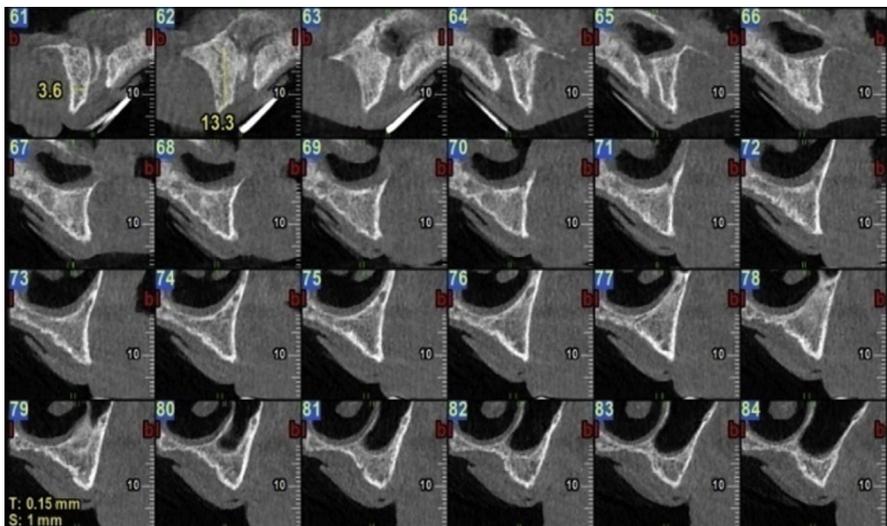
Cross-sectional images obtained from CBCT showing the limited bone volume in the maxilla.
